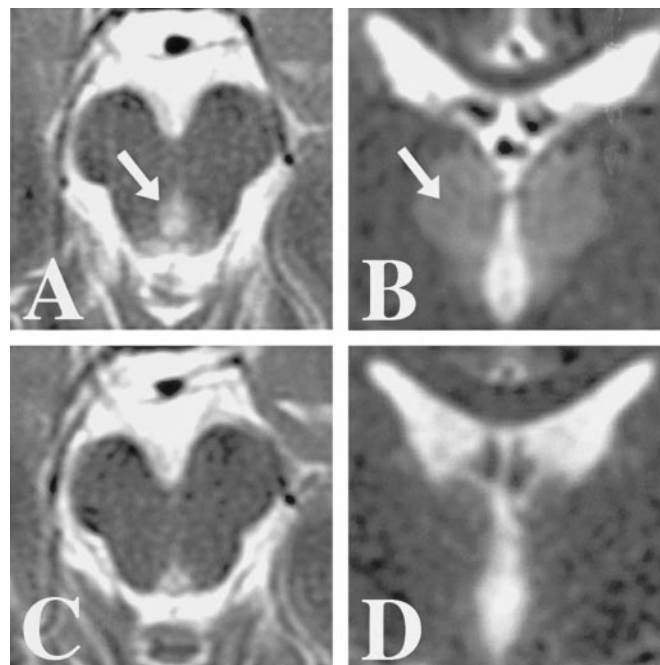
Rapid clearing of MRI signals in Wernicke encephalopathy. T2-weighted MR images at the time of admission show abnormal hyperintense signal (arrows) in the periaqueductal gray region (A, axial view) and dorso-medial thalami (B, coronal view), which cleared after 5 days of thiamine (100 mg IV) treatment (C, D).
